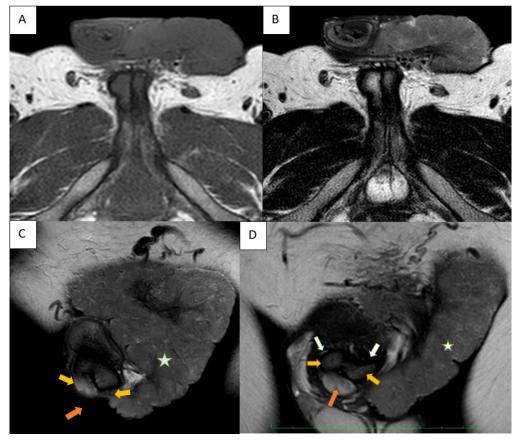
Pelvis MRI. Axial T1 (A) and T2 (B) weighted sequence. Lesion arising from pubic region involving the penis which was isointense in T1 and T2 weighted sequences. T2 weighted coronal images (C and D) showing the relation of the mass with its surrounding structures. T2 hypointense tunica albuginea (white arrows), paired corpora cavernosa (yellow arrows), single ventral corpus spongiosum, mass (white star).
